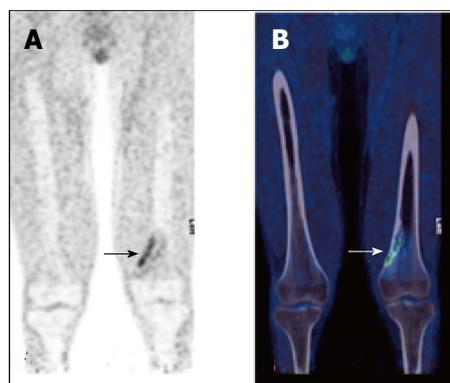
Non-ossifying fibroma (arrow) in the left distal femur of a 17-year-old male patient with Langerhans cell histiocytosis. FDG PET (A) showing avid uptake, CT (B) showing typical benign radiological features. PET: Positron emission tomography; CT: Computed tomography; FDG: 2-deoxy-2-(¹⁸F)fluoro-D-glucose.
